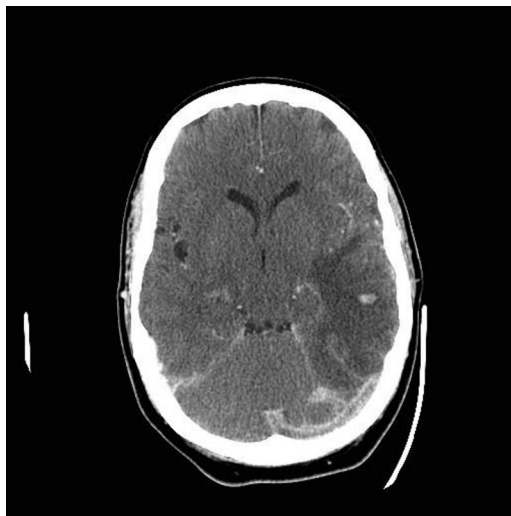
Contrast-enhanced CT of the head showed a large thrombus within the confluence of sinuses, extending into the left transverse and sigmoid sinuses, and a large left-sided venous infarct with haemorrhagic foci involving the left temporal and parietal lobes.
